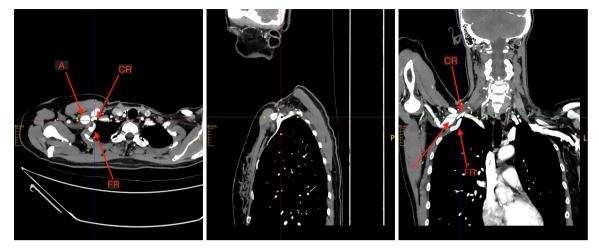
Computed tomography scan with subclavian aneurysm. From left to right: axial, sagittal, coronary views. A, aneurysm; FR, first rib; CR, cervical rib; P, posterior; L, left.
